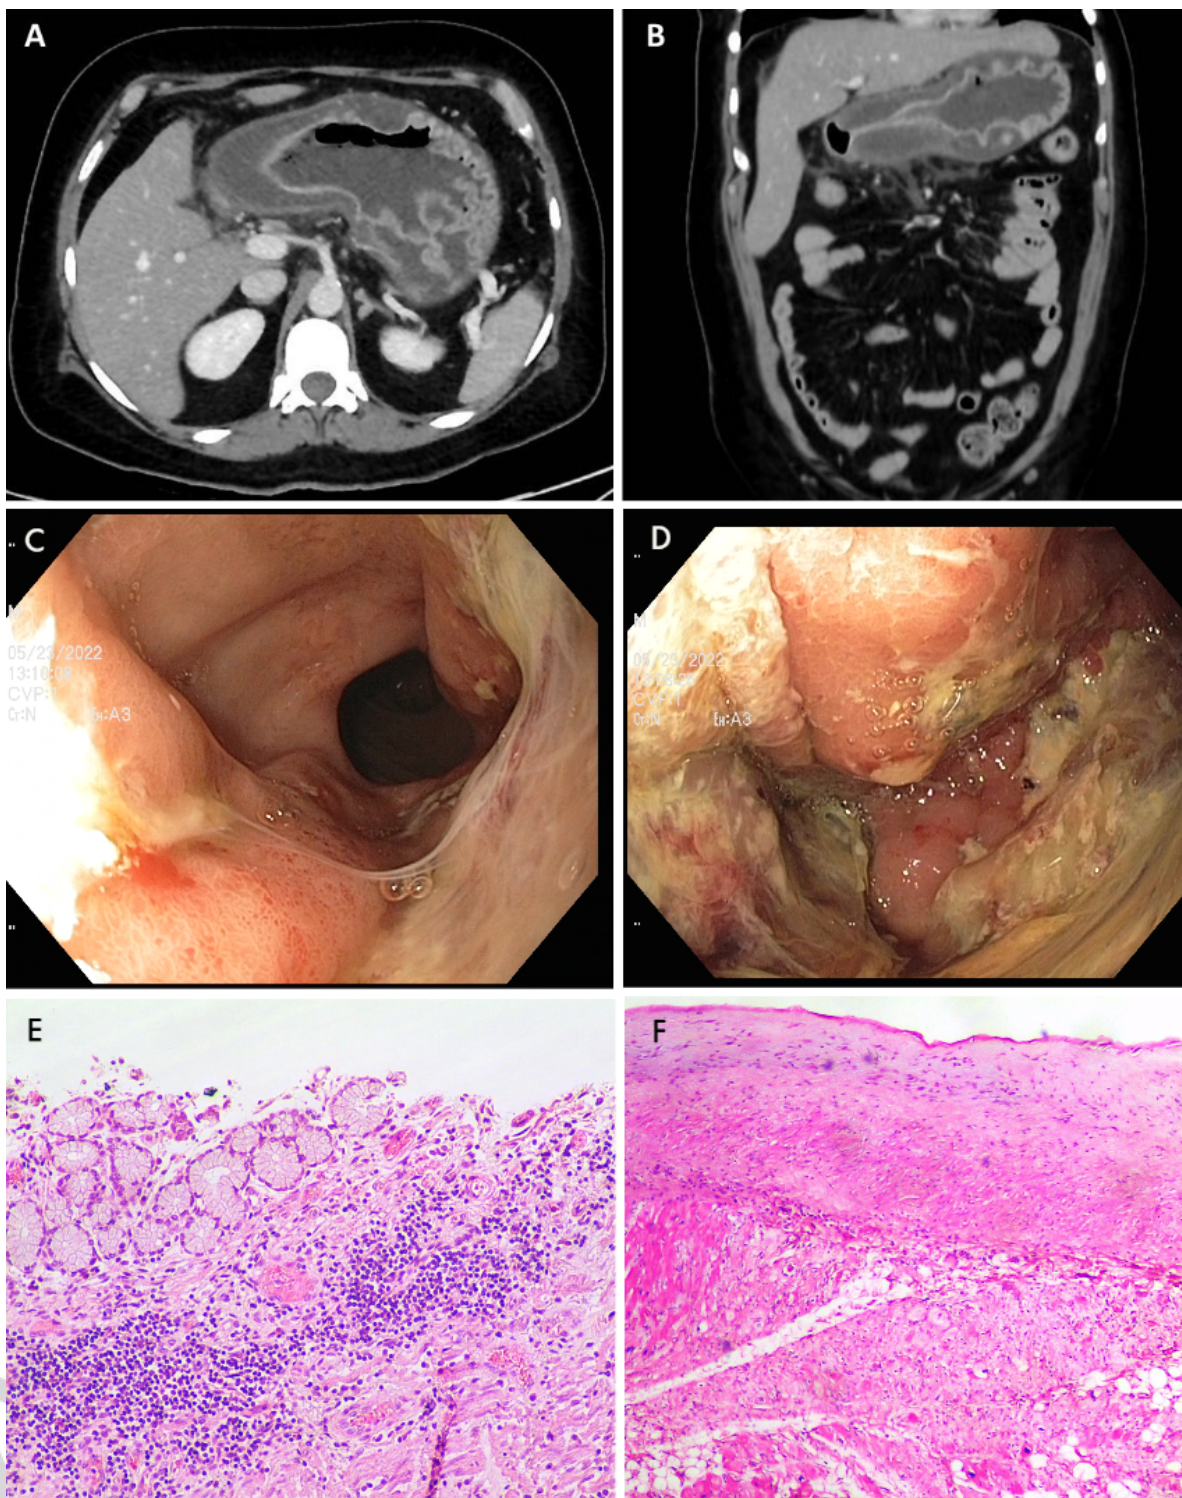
A (axial) and B (coronal). Abdominal computed tomography with intravenous contrast showed generalized gastric wall thickening, submucosal edema and diffuse
